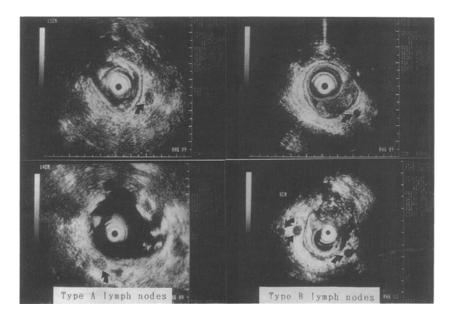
Ultrasonograms showing pararectal lymph nodes. Left. Type A lymph nodes. Right. Type B lymph nodes.
